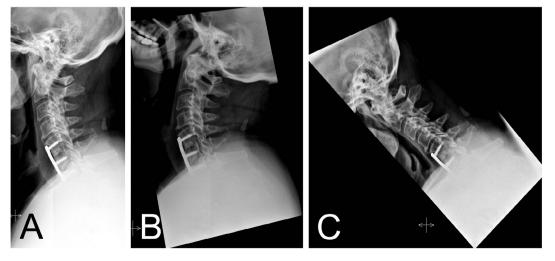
Dynamic X-rays of the cervical spine reveal no pre-operative evidence of anteroposterior motion or interspinous widening suggestive of segmental instability. Lateral, extension, and flexion views shown (A, B and C respectively).
